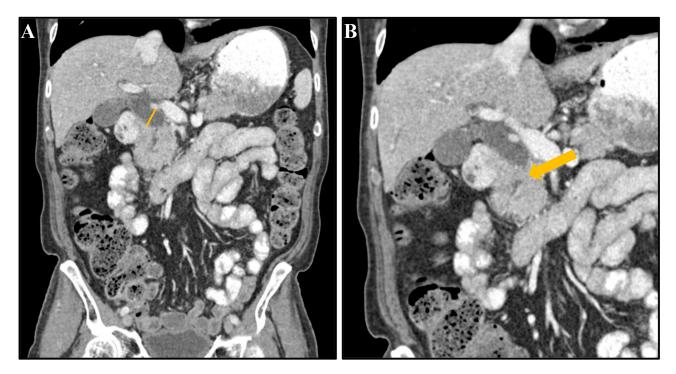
Initial CT abdomen/pelvis demonstrated (a) Severe 18mm common bile ductal dilatation (b) Possible stricture versus mass at the mid distal common bile duct.
